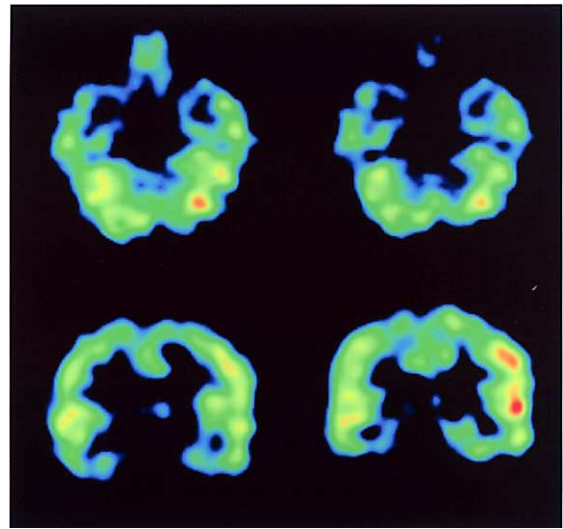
Tc-99m ECD ictal cerebral blood flow SPECT, axial (*upper rows*) and coronal (*lower rows*) images. Regional hyperperfusion in the left temporal lobe is depicted.
